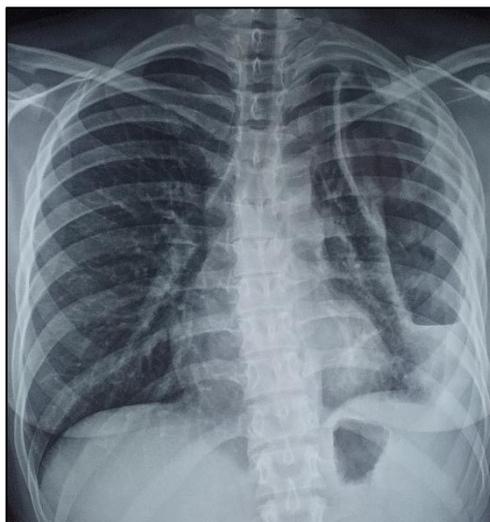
Frontal thoracic radiograph showing a left hydropneumothorax with thickening of the visceral and parietal pleura
